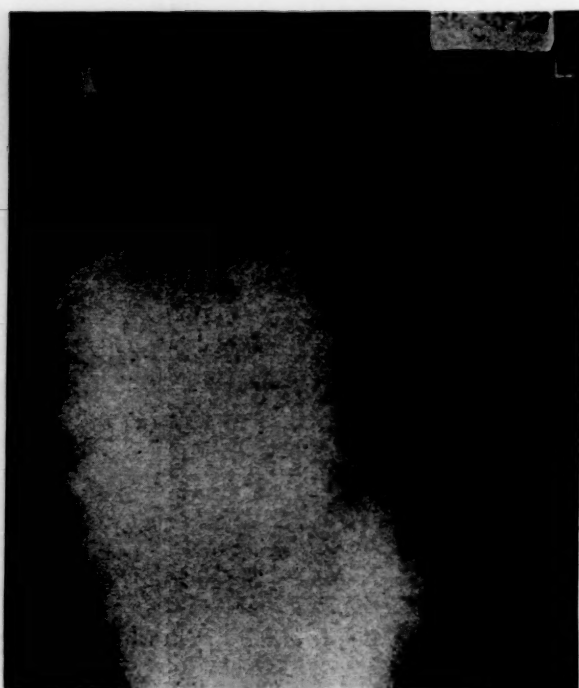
Case 1. X-ray of chest showing extensive osteolysis and pleural effusion.
